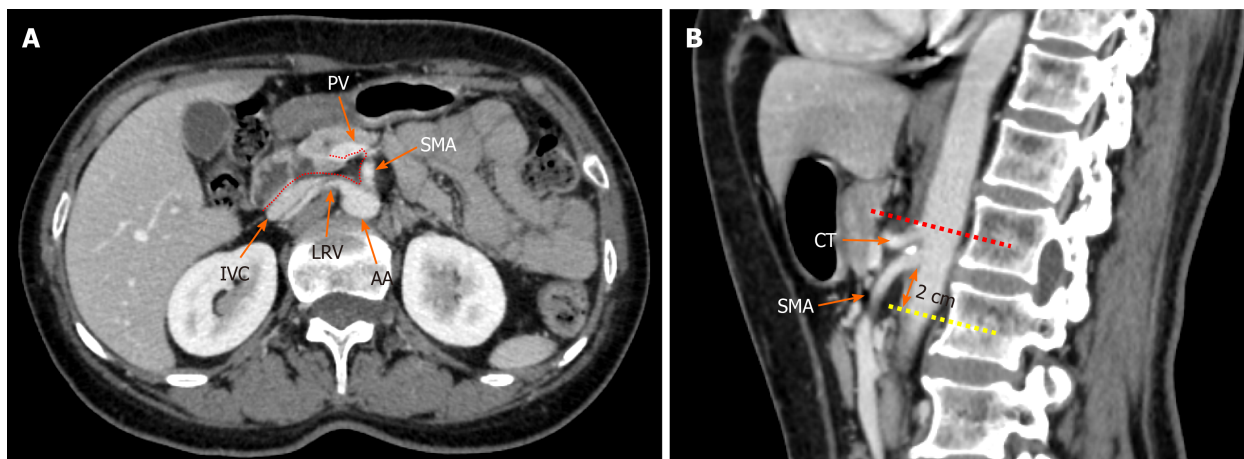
Radiological depiction of the mesopancreas in computed tomography. A: The dotted line outlines the boundary of the mesopancreas, a region identified as the retro pancreatic retro portal tissue; B: The inferior boundary of the mesopancreas is 2 cm below the origin of superior mesenteric artery. PV: Portal vein; SMA: Superior mesenteric artery; LRV: Left renal vein; IVC: Inferior vena cava; AA: Aorta artery; CT: Celiac trunk.
